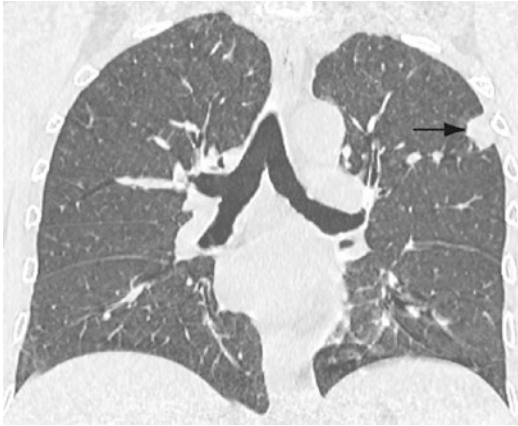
Coronal non-enhanced computed tomography of a transplanted patient with pulmonary cryptococcosis demonstrates a subpleural left upper lobe solid nodule (black arrow)
